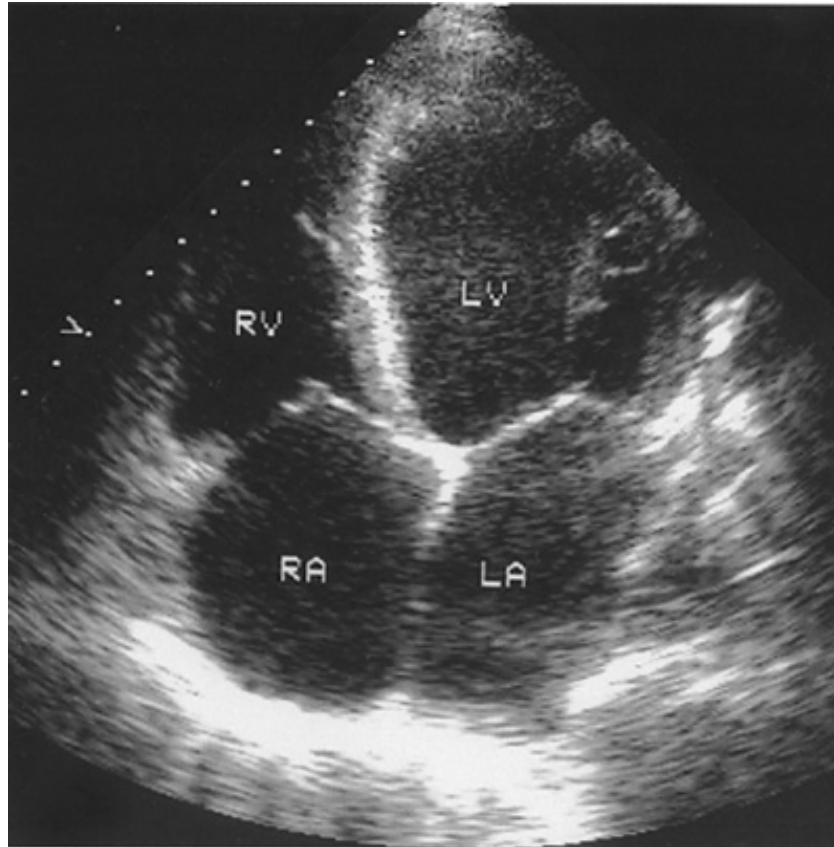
Apical four-chamber image of dilated cardiomyopathy. There is four-chamber enlargement as well as left ventricular (LV) spontaneous echo contrast. RV = right ventricle; RA = right atrium; LA = left atrium.
